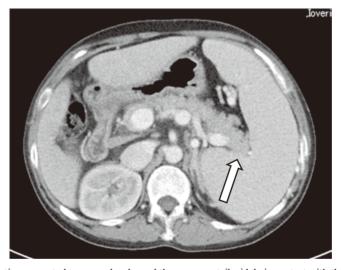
Preoperative computed tomography showed the pancreas tail widely in contact with the spleen (arrow).
